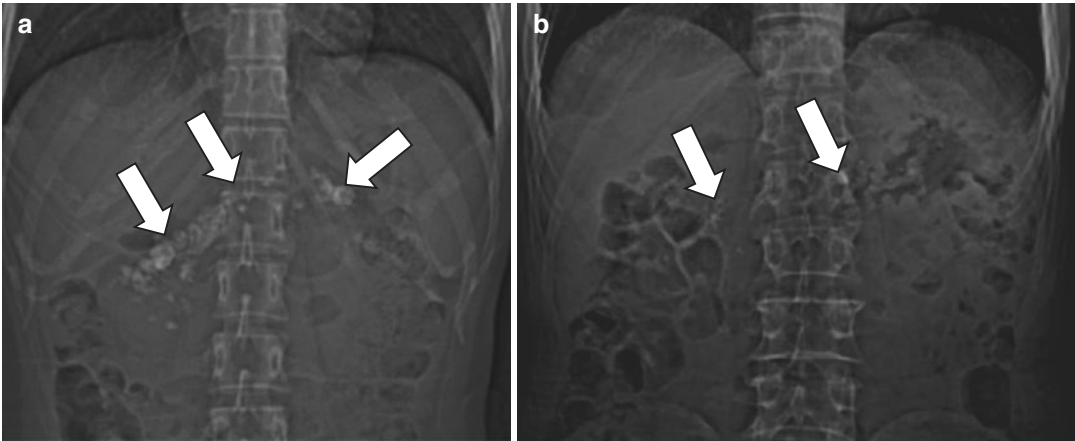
Chronic pancreatitis on plain abdominal radiographs. (a, b) Of two alcoholic patients show multiple coarse calcifications in the topography of the pancreas (arrows)
